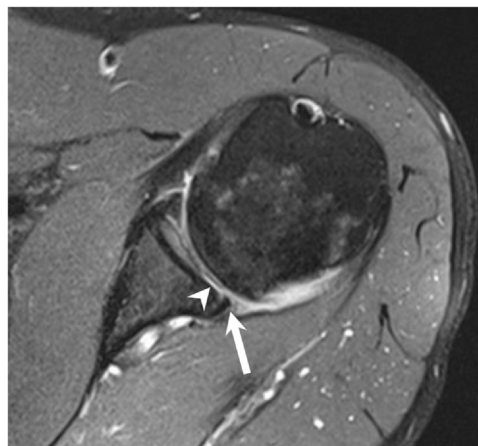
Elite baseball pitcher presents with shoulder pain at the conclusion of the baseball season. Axial PD FS MR image demonstrates tearing of the posterior labrum (arrow), which destabilizes the glenohumeral joint. There is associated high-grade cartilage loss along the posterior glenoid (arrowhead). FS, fat saturation; MR, magnetic resonance; PD, proton density.
